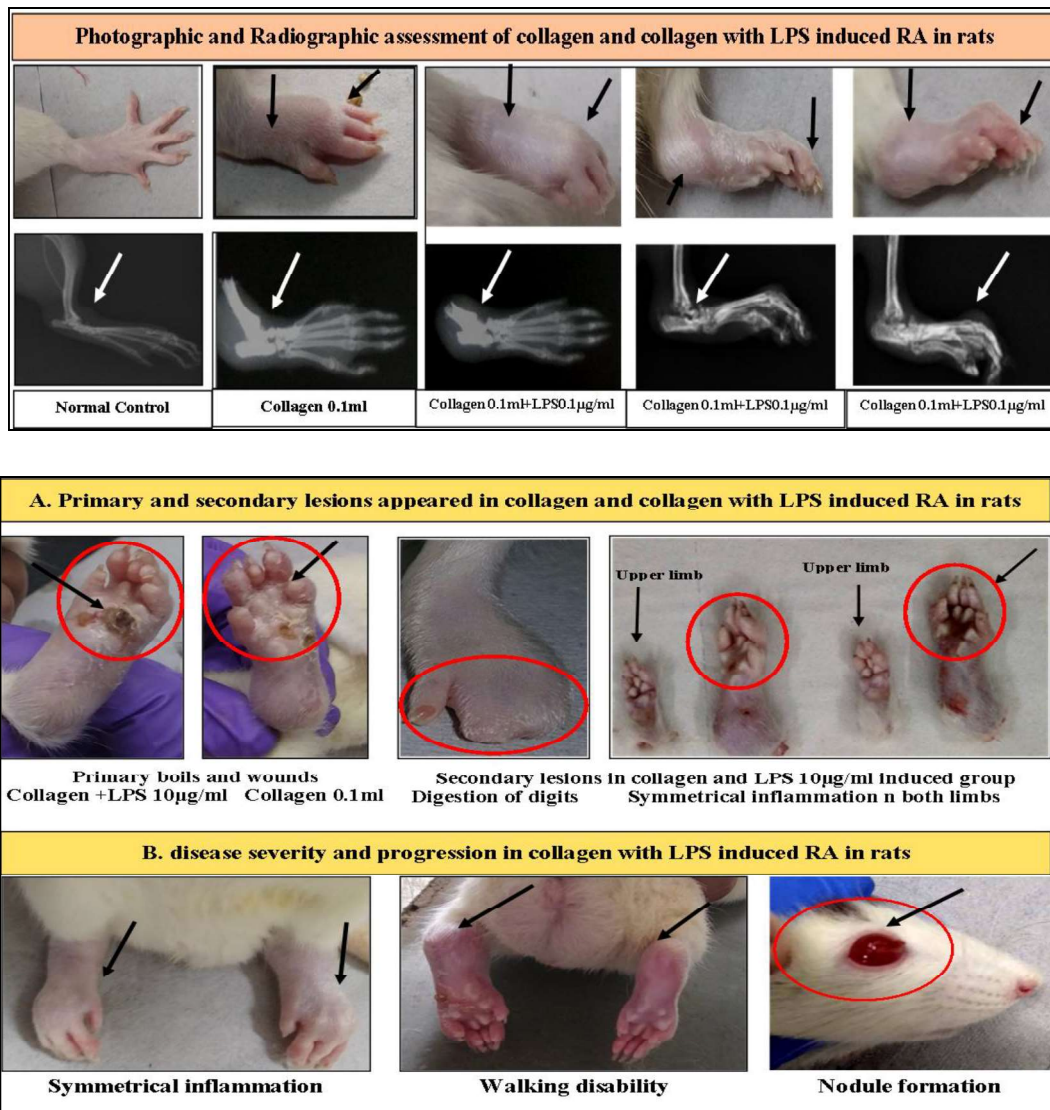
Photographic and Radiographic assessment of collagen and collagen with LPS induced RA
